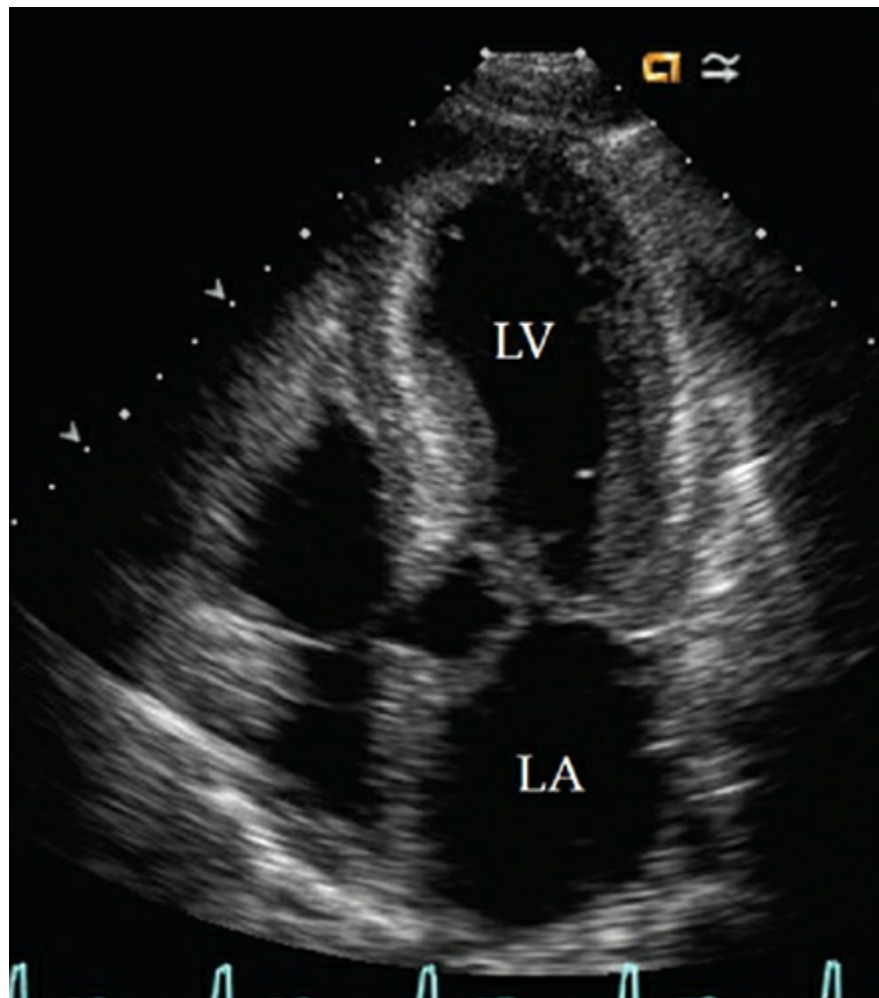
Apical four-chamber view during systole, demonstrating systolic anterior motion of the mitral valve. LA, left atrium; LV, left ventricle; RA, right atrium.
